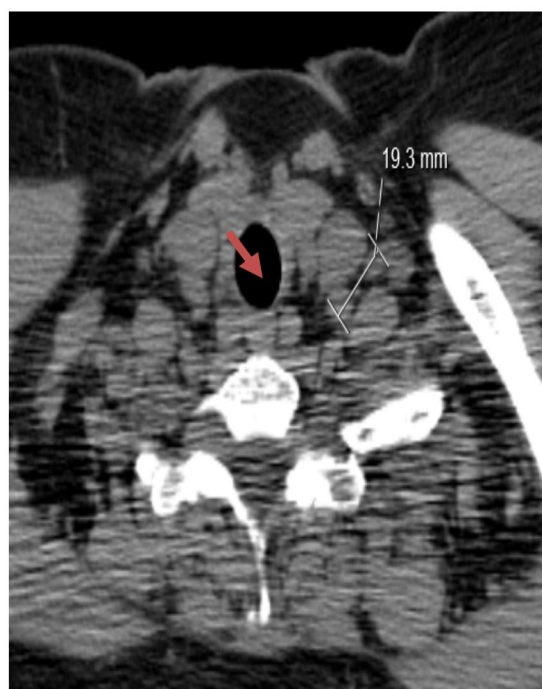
An axial section of a CT scan in 2007 showing a 19.3 mm mass in the left supraclavicular area consistent with lymph node metastasis (arrow).
